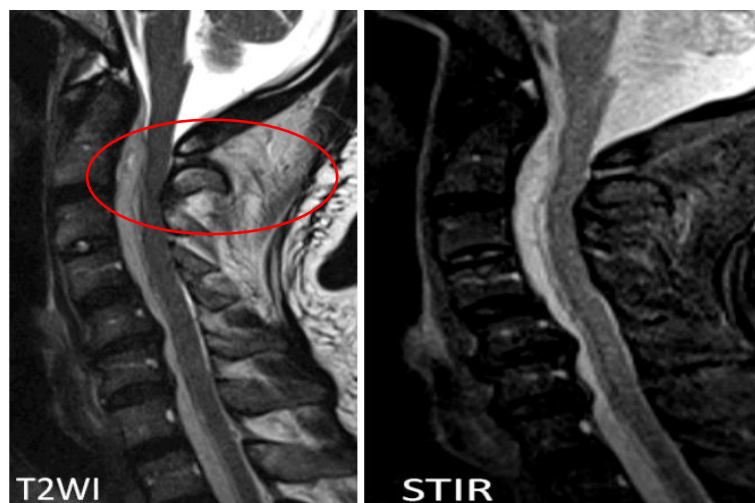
Patient 3- MRI spine showingmeningitis &epidural abscess
